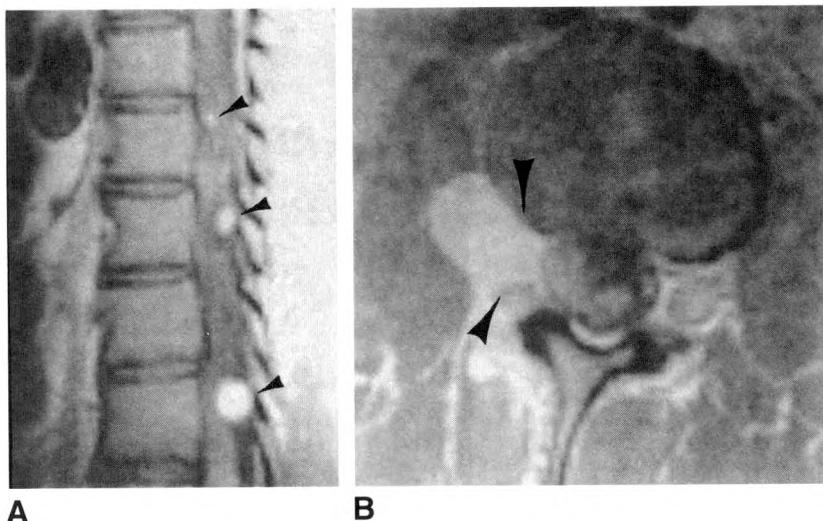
MR imaging findings in 9-year-old boy with neurofibromatosis and scoliosis. Acute levoscoliosis of thoracolumbar spine is shown on coronal T1-weighted (500/20) image.
